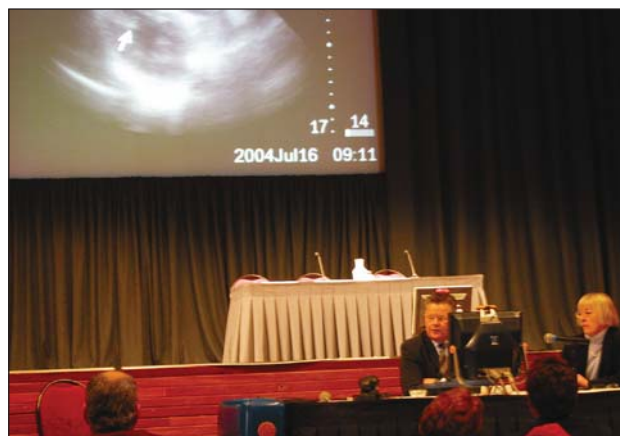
Associate Prof. Gerry Wilkins monitors and discusses transmitted echocardiogram.
